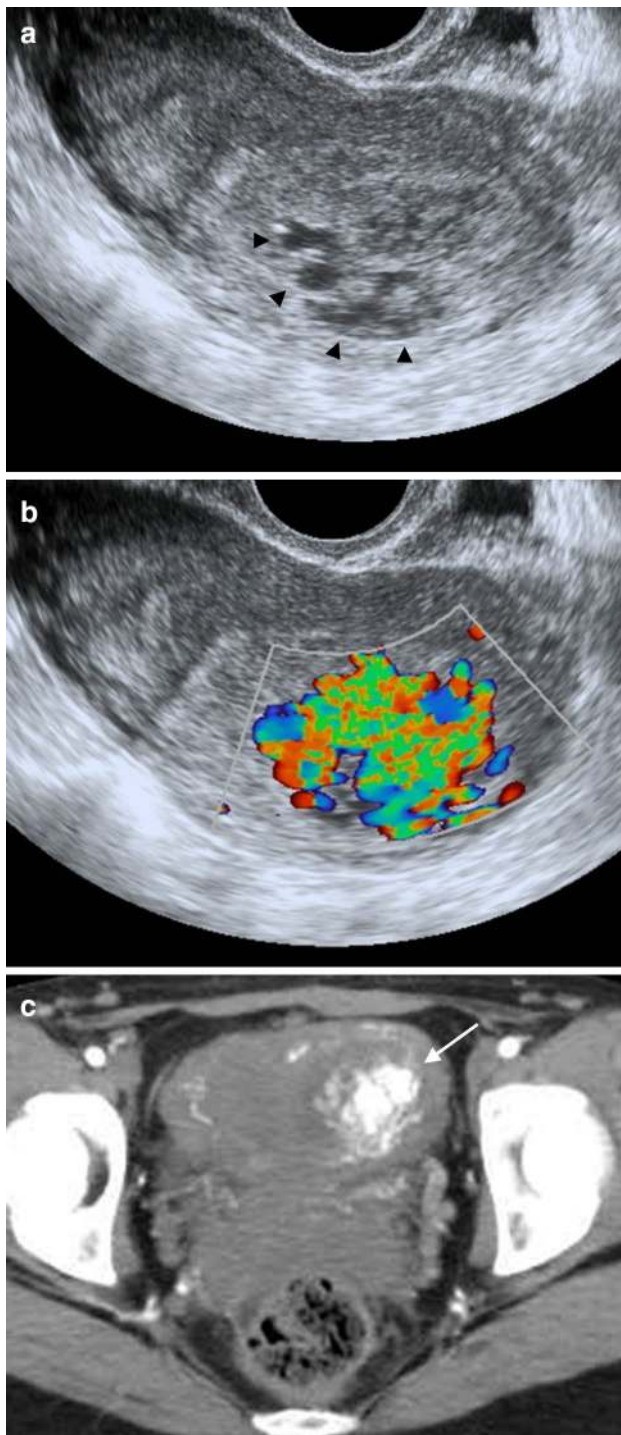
24-year-old woman, 6 weeks after septic abortion at 16 weeks' gestation. a, b Doppler ultrasound shows myometrial anechoic spaces (arrowheads) with prominent vascular flow. c Contrast-enhanced CT shows a hypervascular lesion (arrow) corresponding to the myometrium. The genital bleeding was not severe, and the vascularity of the lesion gradually decreased and finally disappeared, suggesting spontaneous regression of a uterine vascular malformation
